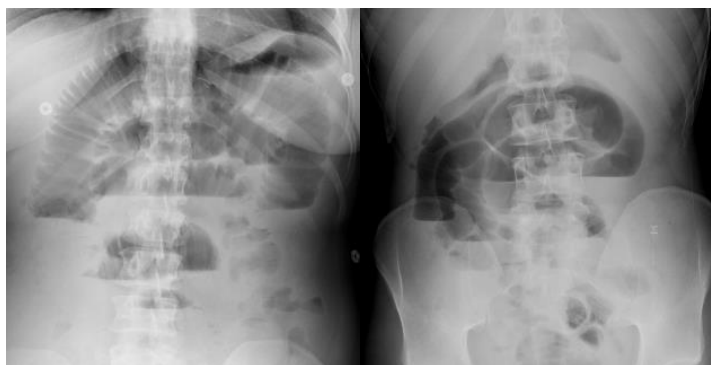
A plain abdominal X-ray film showed dilatation of small bowel loops and the presence of multiple air-fluid levels.
